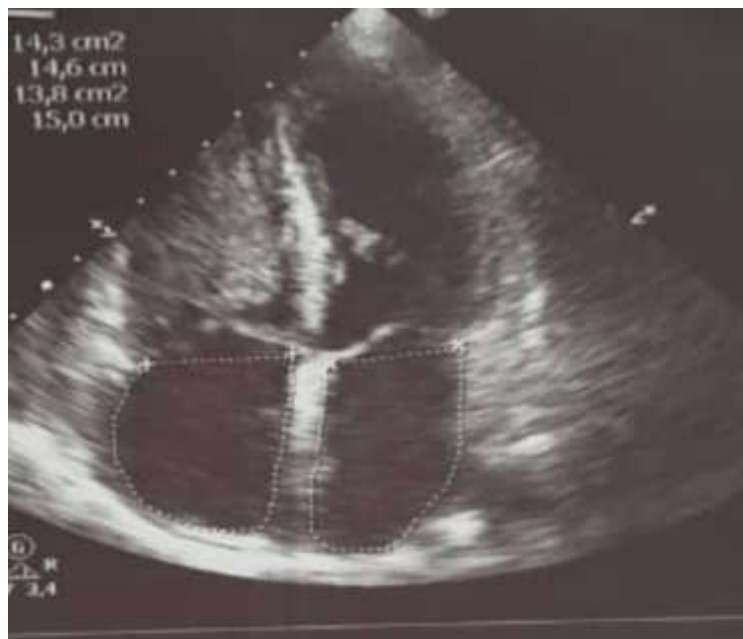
Echocardiographic image in apical 4-chamber showing right and left intraventricular thrombus.
